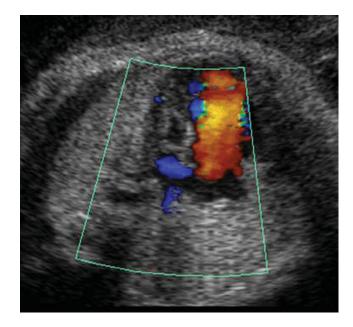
Axial image with color Doppler demonstrating absence of forward flow across mitral valve consistent with hypoplastic left heart syndrome.
